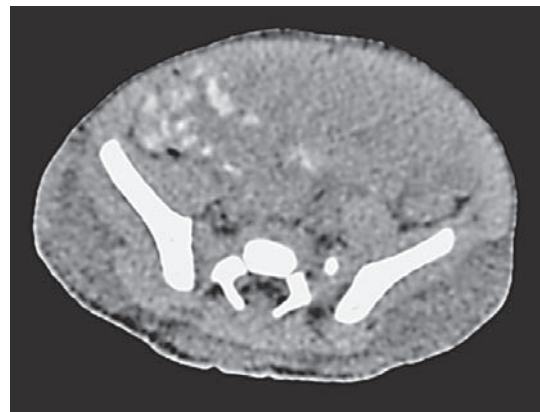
Computed tomography: hyperdensity in the gluteal region.
